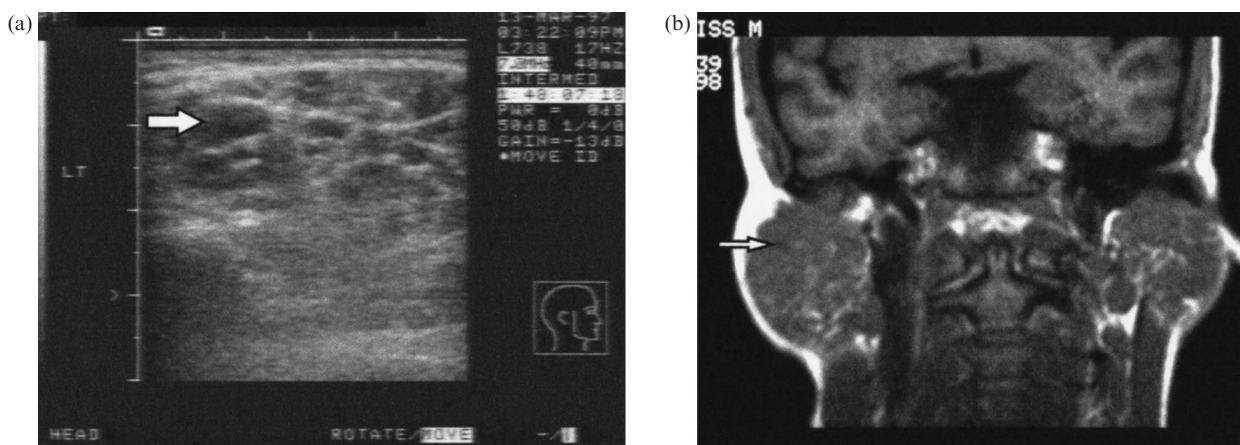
Parenchymal patterns of the parotid gland on US (a) and MRI (b) examinations in a 54-yr-old SS patient with B-cell lymphoma. (a) US: unusually large, ill-defined hypoechoic area with a 'cobblestones'-like internal pattern ( $\Rightarrow$ ) in the parotid corresponding to the lymphoma. (b) MRI: almost homogeneous fine reticular pattern of the lymphoma involving the whole parotid gland ( $\Rightarrow$ ).
